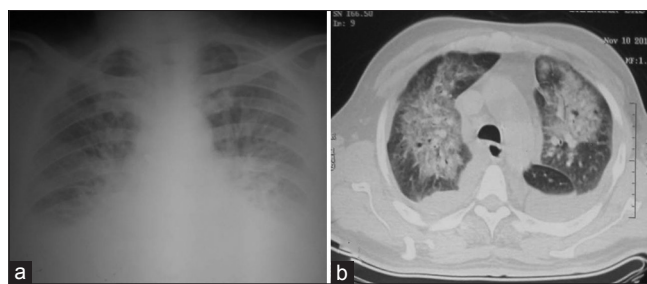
(a) Chest radiograph showing pulmonary edema and bilateral pleural effusion. (b) Computed tomography chest showing ground glass opacities, interlobular septal thickening, and bilateral effusion
